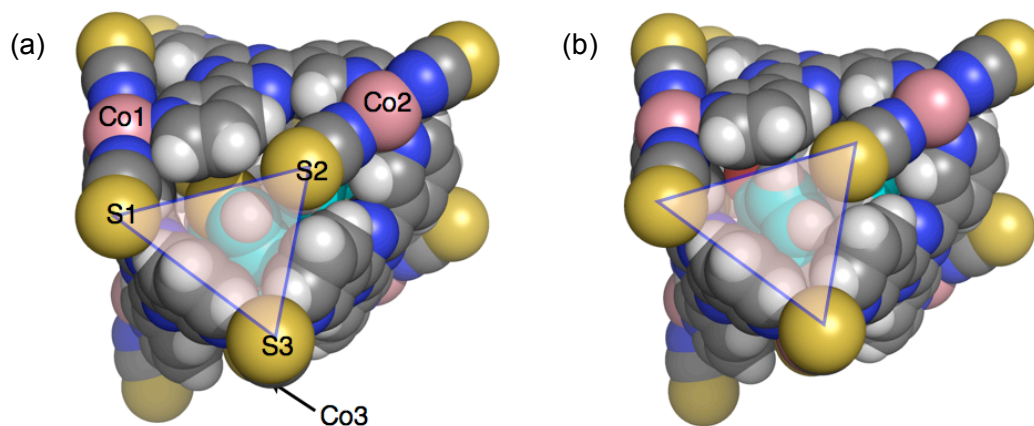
X-ray structure of one capsule unit in (a) $2\text{D}(7)_4$ and in (b) $2\text{D}(8)_2$ (shown in CPK model). (blue triangle represent the aperture of capsule)
